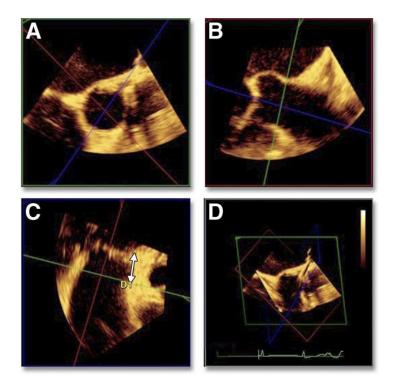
AA-LM distance measured by 3DTEE. Example of 3-dimensional (3D) transesophageal (TEE) measurement of the distance between aortic annulus (AA) and left main coronary ostium (LM). The 3D dataset was analyzed through 3 different orthogonal cut planes: green plane (A) is a short axis view of aortic root crossing the LM; red (B) and blue (C) planes are sagittal views of the ascending aorta. The blue plane was gradually rotated until the LM appeared allowing the measurement of the distance between AA and LM ostium (white arrow). (D) The position and the relationship of each plane in the 3D dataset are shown.
